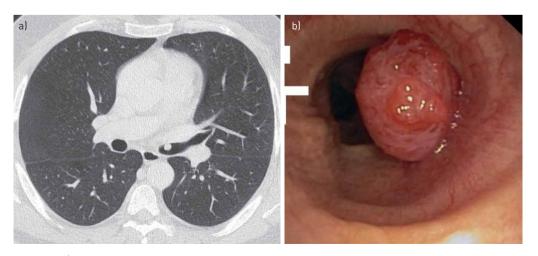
a) Initial computed tomography scan with an endobronchial lesion in the left main bronchus. b) Initial bronchoscopy with an exophytic well-vascularised polypoid lesion.
